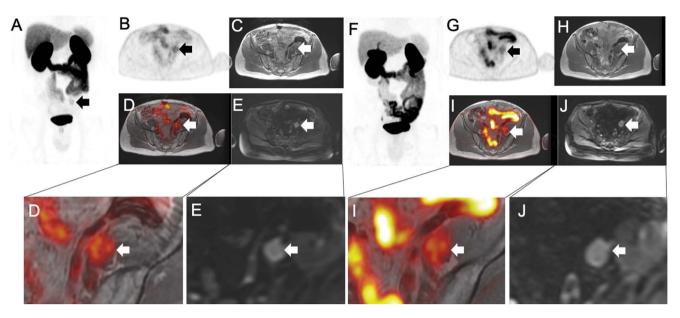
<sup>68</sup>Ga-PSMA PET/MRI showed mildly increased radiotracer avidity in the left external iliac region on the body maximum intensity projection (MIP) image (A, arrow), which was localized to moderate radiotracer uptake (B, arrow, PET) in the enlarged left external iliac node (C, MRI) (D, fused PET/MRI) with restricted diffusion (E, arrow, diffusion-weighted imaging (DWI)). <sup>18</sup>F-BF3-Cy3-ACUPA PET/MRI showed increased abnormal radiotracer avidity in the left iliac node (F, body MIP; difficult to delineate due to overlying bowel activity; G, arrow, PET and H, MRI and I, fused PET/MRI) with restricted diffusion (J, arrow, DWI MRI).
